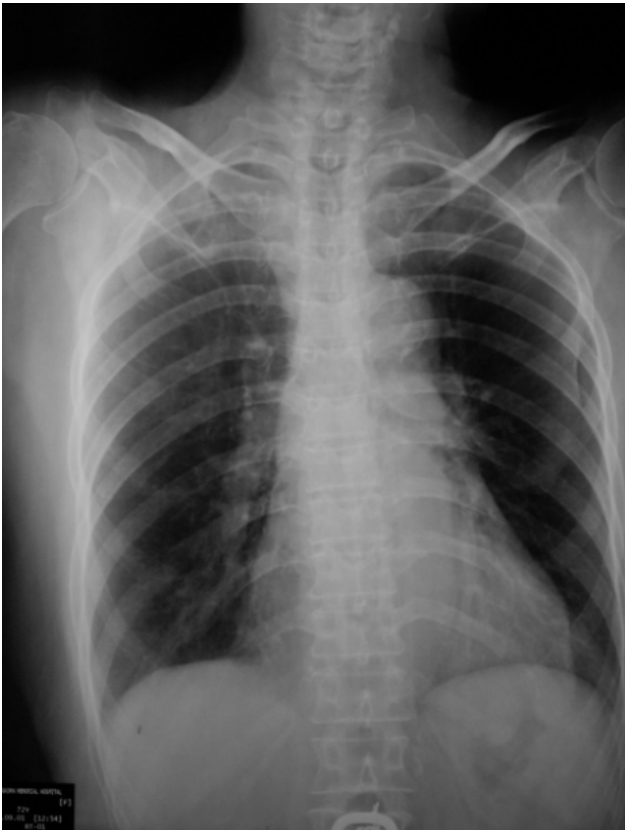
Chest radiography before glue injection
